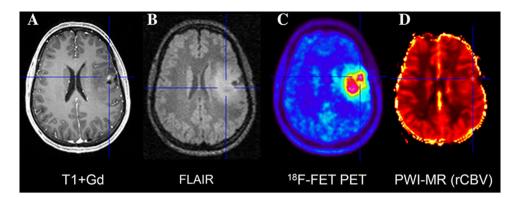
Hybrid PET/MRI of patient with an astrocytoma WHO grade II. Contrast-enhanced T1-weighted MR imaging (A) shows a small area with contrast enhancement in the left frontal lobe while FET PET
